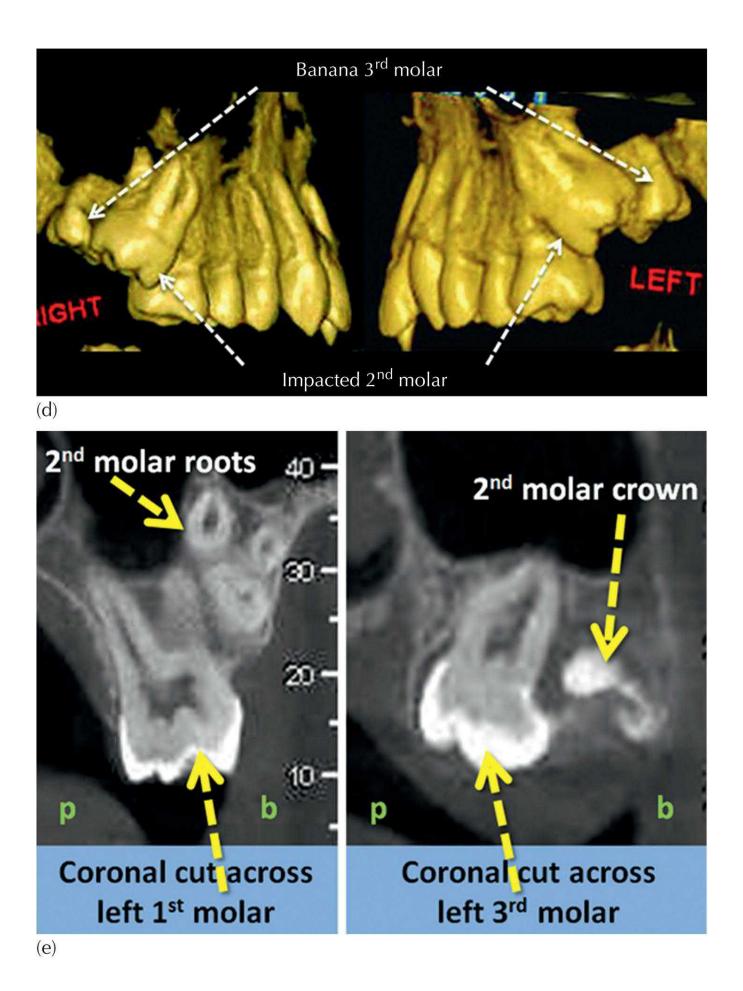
The 'banana' maxillary third molar. (a) In the panoramic view of a 13-year-old female, the left maxillary third molar is superimposed on the impacted second molar and is more occlusally located. The other second molars have erupted. (b) The extracted 'banana' molar from the occlusal and buccal aspects, showing its anomalous form. (c) The second molar erupted autonomously, four months after the extraction, although the panoramic view was taken many months later, at the completion of the orthodontic treatment. (d) 3D screenshots taken from the cone beam computed tomography of the patient show the extreme crowding that is present at the distal end of the maxillary alveolus. In order to accommodate the unerupted molar teeth, the roots of the second molars are severely displaced mesially and buccally, nestling in the distal concavity at the distobuccal aspect of the first molars. The third molars are developing disto-lingually and inferiorly, apparently confining the second molar with their mesially bulging morphology to prevent any vertical movement. (e) The vertical (cross-sectional) 'cut' across the alveolus of the left first molar shows the location of the three-rooted second molar on its buccal side. The cut that traverses the palatally displaced third molar shows its bulbous mesial cusp and the depression in the cemento-enamel junction area and how these may trap the more superiorly placed second molar from erupting vertically downwards towards its place in the arch.
